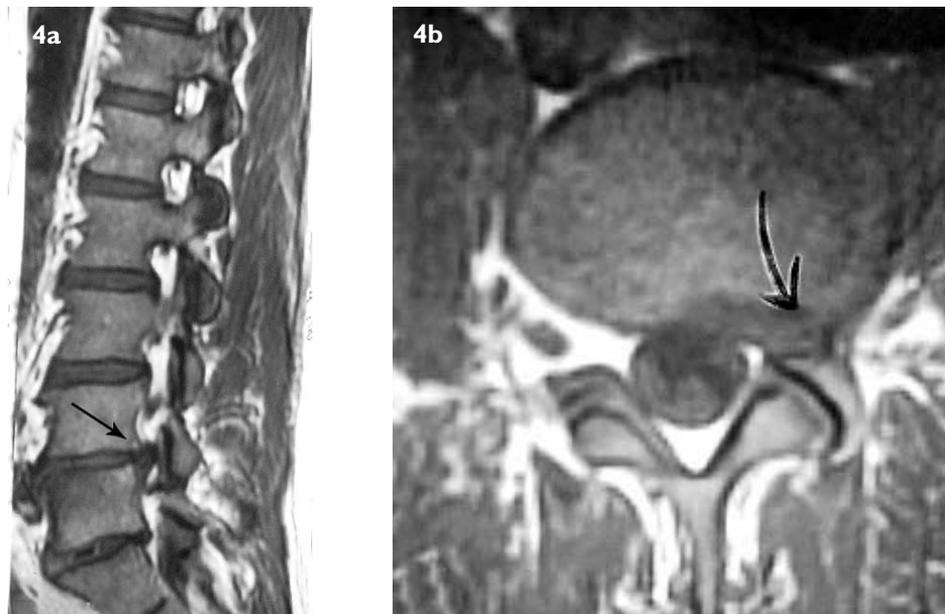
(a) Sagittal and (b) axial T1-W MR images show a left foraminal disc protrusion at L4-L5 level (arrow) without significant root compression.
